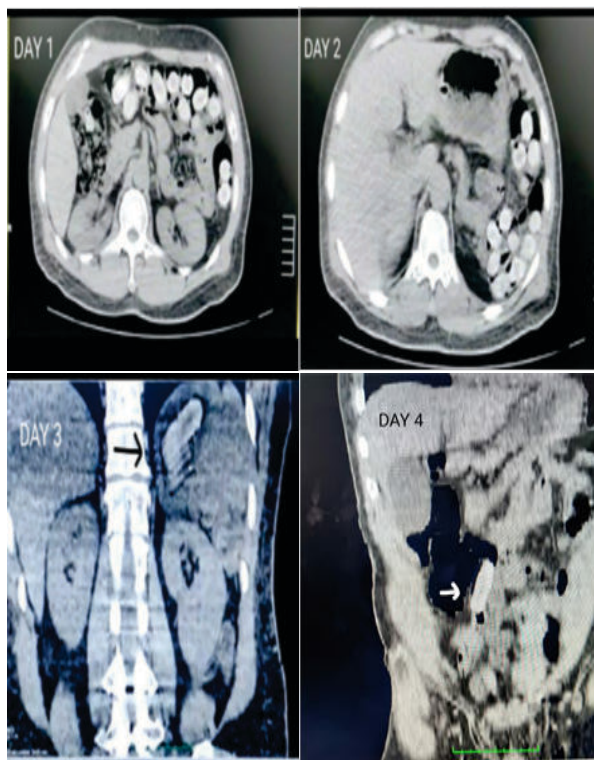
CT Scan Images depicting the contraband substance packets in bowel loops.
